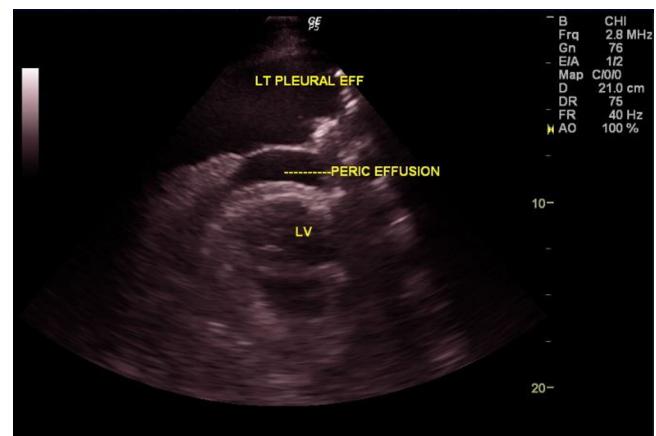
Echocardiography showing massive pericardial effusion.
